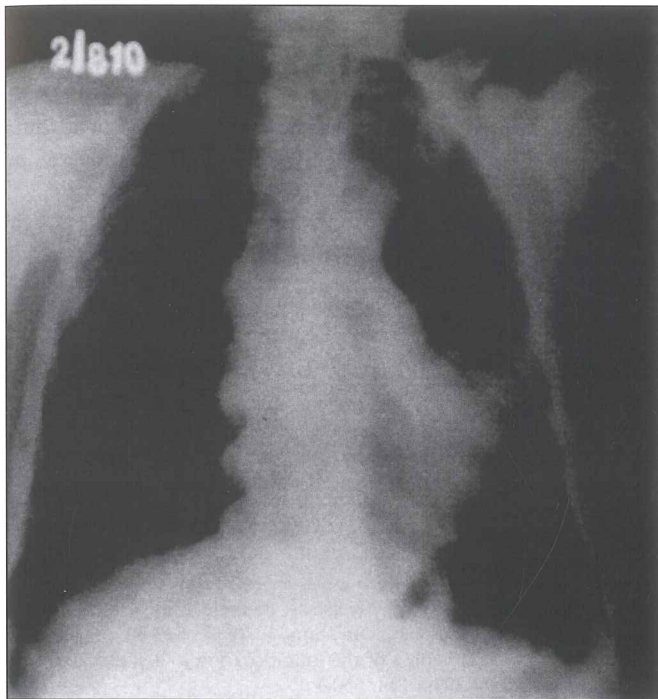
Chest X-ray showing an increase in density in left lower and right middle lobes.
